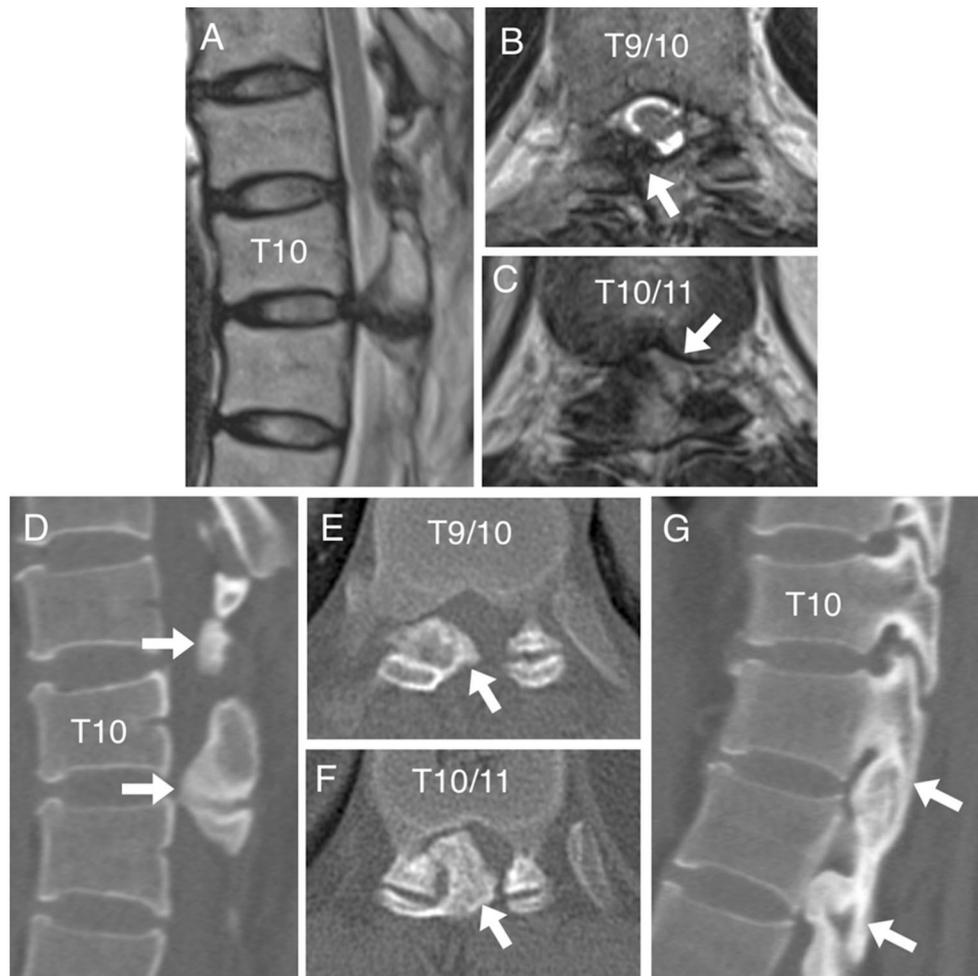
Case 1. MR images and CT scans obtained before the second operation. Sagittal (a) and axial (b, c) T2-weighted images show the compressed spinal cord at the T9–10 and T10–11 intervertebral levels (arrows in b, c). Sagittal reconstruction (d) and axial (e, f) CT scans
